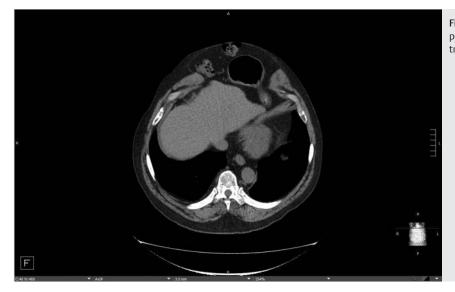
Cross-sectional abdominal CT scan of patient with large incisional hernia after liver transplantation.
